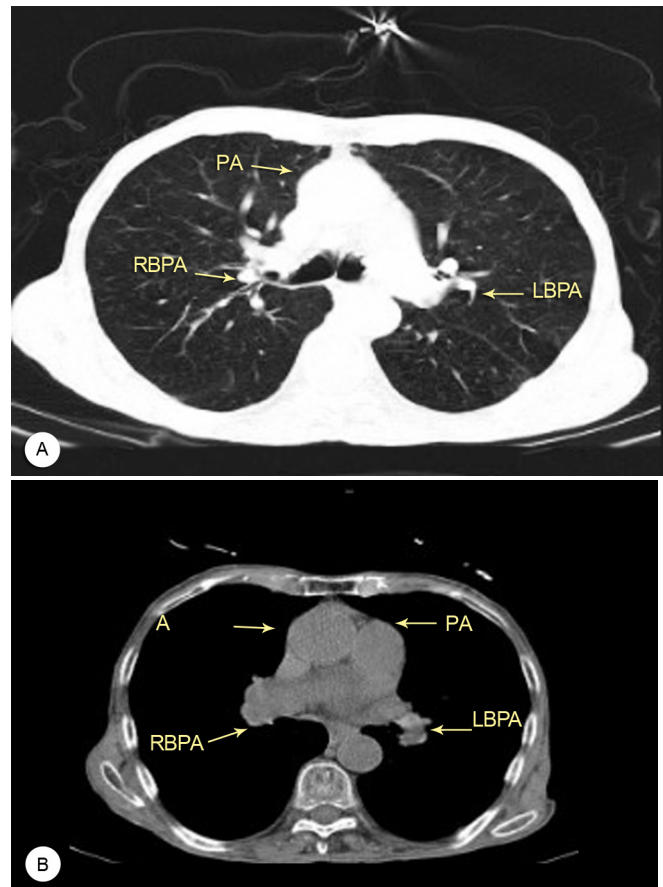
Two views of the patient's chest computed tomography scan demonstrate normal pulmonary parenchymal (A=parenchymal view), as well as the main PA and its branches (B=mediastinal view).
